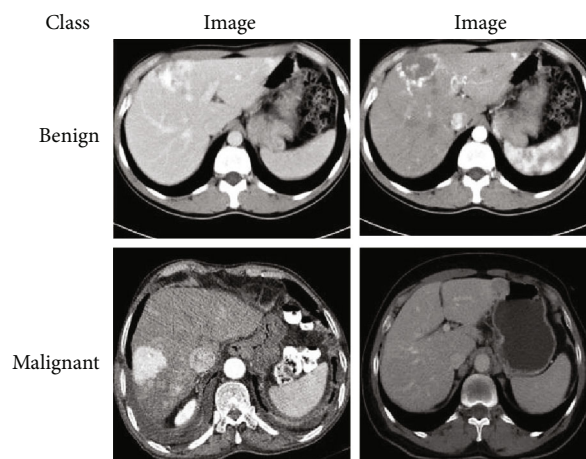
Liver CT scan images.
